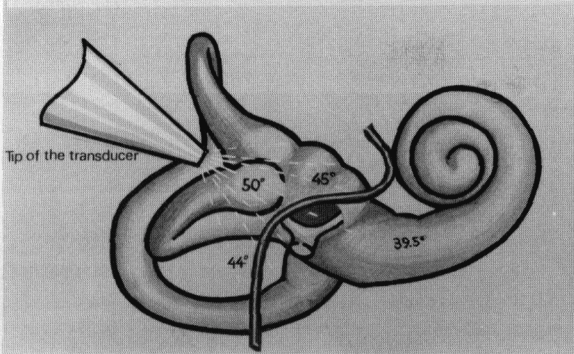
Way in which heat energy is distributed in temporal bone during ultrasonic irradiation.
